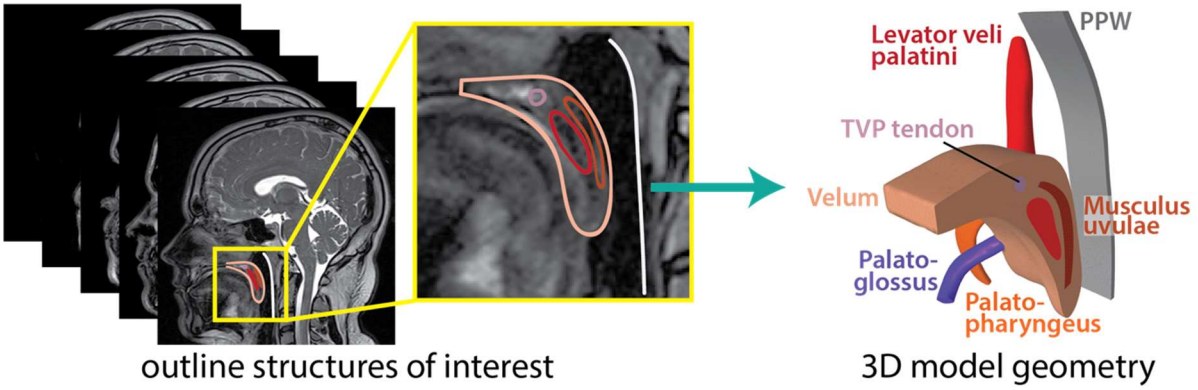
Creation of model geometry from three-dimensional static MRI
